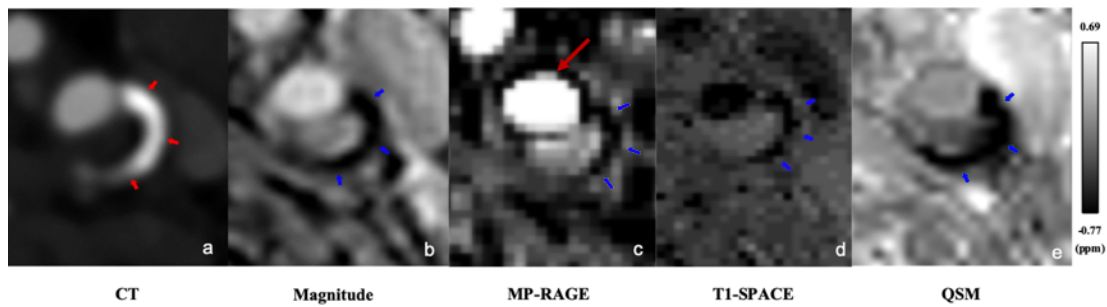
A hyperdense calcified component of a plaque depicted in the left carotid artery on a CT image (a). At the same position, SWI magnitude (b), MP-RAGE, where red arrow indicates flow artifacts (c), T1-SPACE (d) and QSM (e). Note that the susceptibility in the area of the calcification (blue arrows) is hypointense (with a mean susceptibility value of -0.89 ppm compared to the adjacent arterial blood) revealing a diamagnetic substance. The mean susceptibility value of the vessel wall is -0.28 ppm compared to the adjacent arterial blood.
